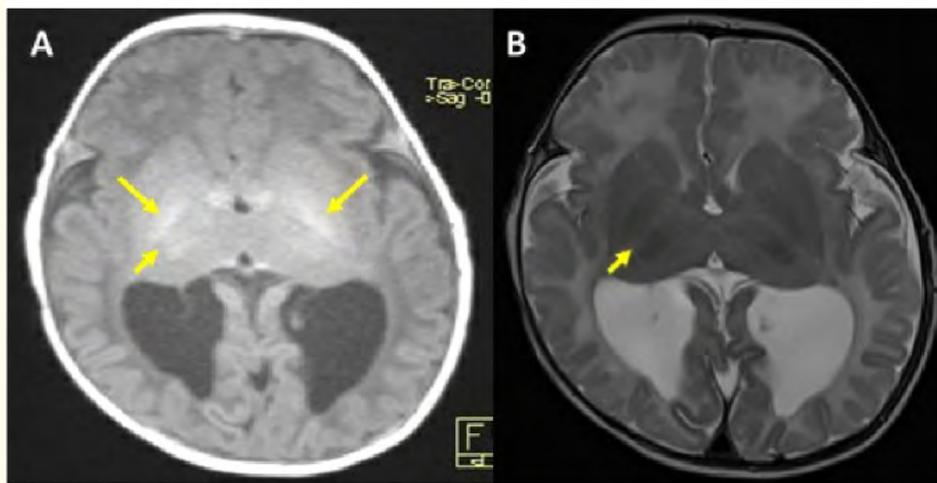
(A) T1W and (B) T2W Axial MRI images of the brain at the level of basal ganglia.
